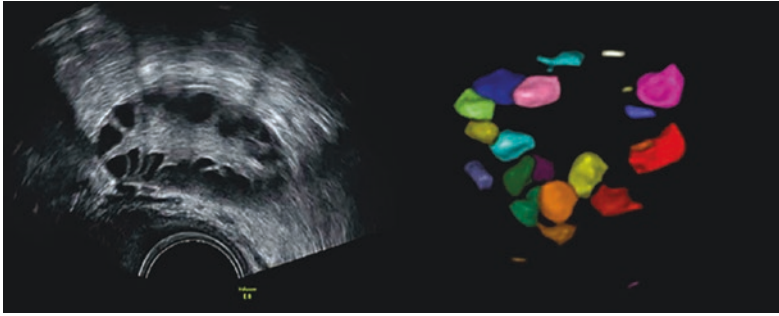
PCO-typical ovaries in transvaginal ultrasound. The classic pearl string-like arrangement of the follicles is depicted. (With kind permission of Prof. Dr. Brezinka, MUI Innsbruck)
